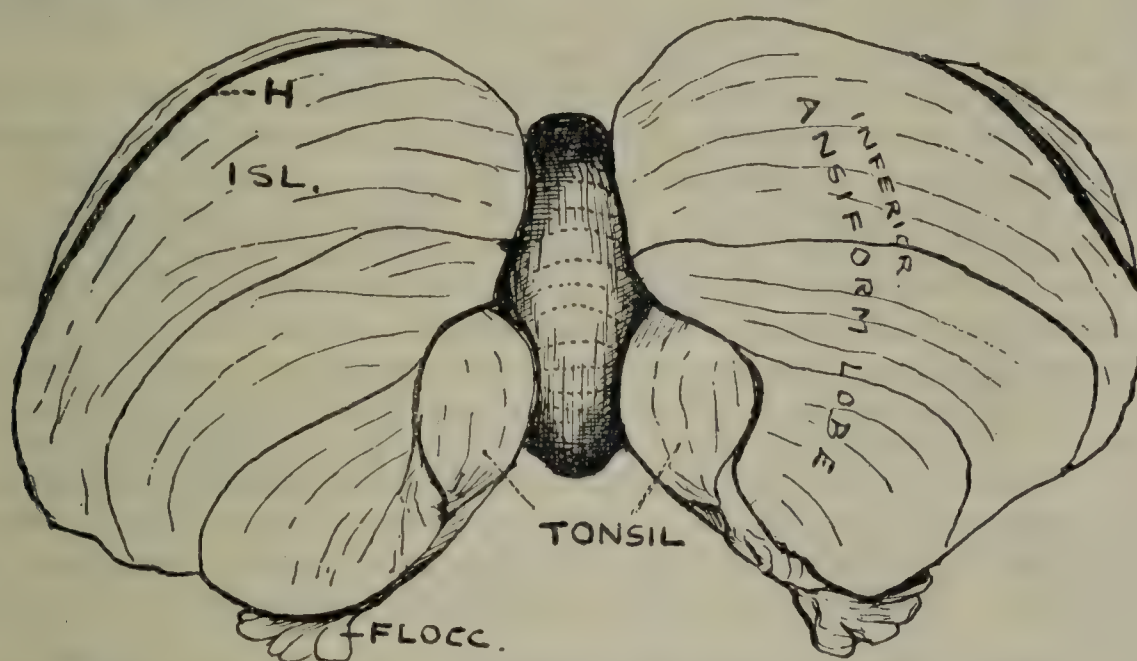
LOWER ASPECT OF CEREBELLUM, SHOWING THE (INFERIOR) ANSIFORM LOBE AND THE PARAMEDIAN LOBULE OR TONSIL; ALSO THE FLOCCULUS.
